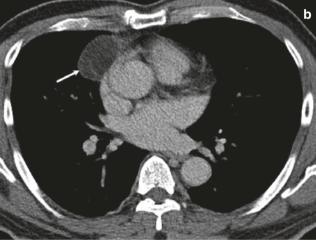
Thymolipoma in the paracardiac location. (a) Frontal radiograph shows focal opacity (arrow) silhouetting and bulging out of the right heart border with "hilum overlay" sign present as pulmonary vessels can be seen through it. (b) Axial CT image shows a well-circumscribed, fatty soft tissue containing right paracardiac mass (arrow) in the anterior mediastinum
